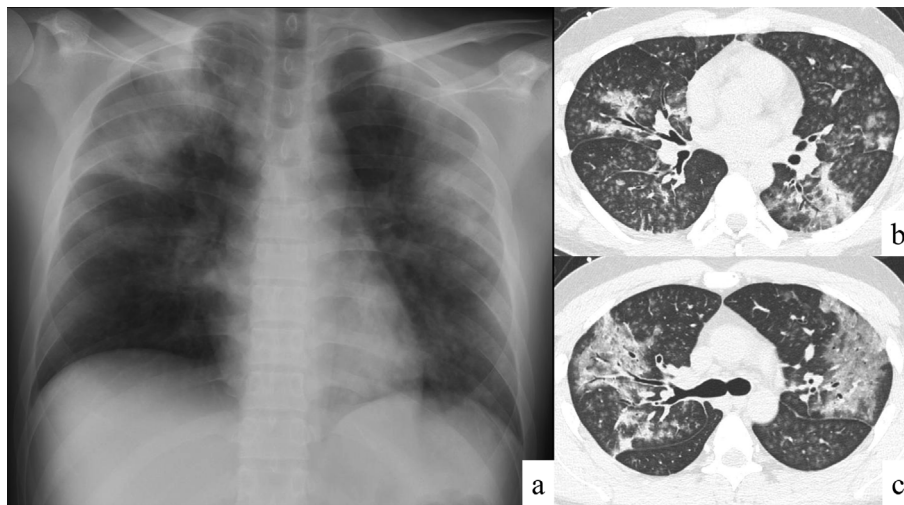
Chest imaging of case 1. Chest X-ray showed bilateral ground-glass opacities (GGOs) and consolidations (a). Chest computed tomography (CT) showed bilateral GGOs and centrilobular nodules (b, c).
